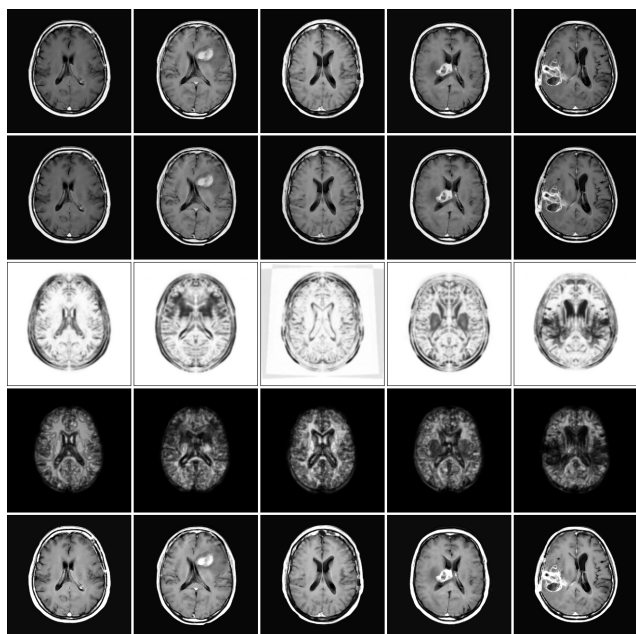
Intensity Standardization of real data. Top row: T1-weighted images from 5 patients. Second row: Intensity Standardization based on unweighted linear regression. Third row: Symmetry weighting based on T1-weighted and (coregistered) T2-weighted image. The three abnormal regions have clearly had their weight reduced. Fourth row: Combined weighting. The estimation for most of the images is primarily based on white matter regions, although some images also have high weights assigned to csf and gray matter regions. Bottom row: The results of Intensity Standardization. It is obvious that the differences in intensity between images have been significantly reduced.
